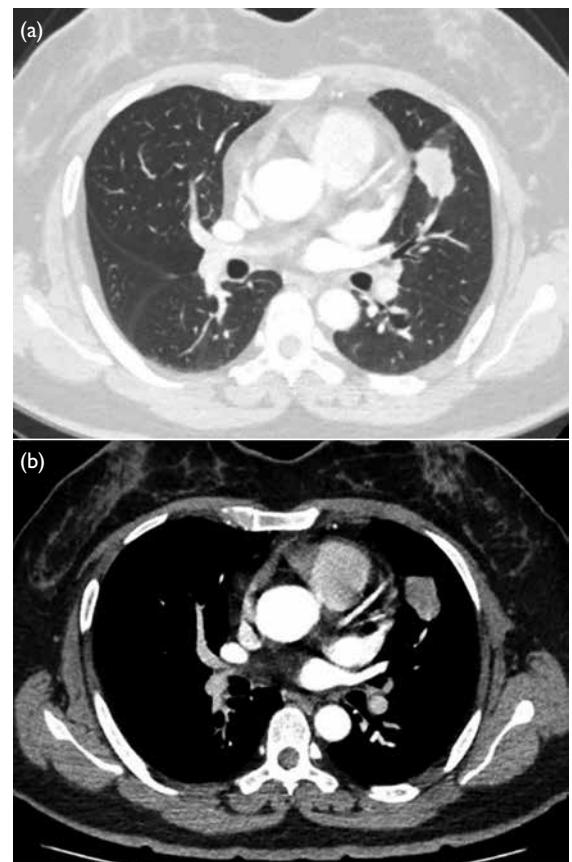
(a) Plain computed tomography imaging of the left upper lobe demonstrates a 21 × 27 mm² lobulated nodule with well-defined margins. (b) Contrast-enhanced scan reveals marked heterogeneous enhancement of the lesion and occlusion of the adjacent proximal bronchus
